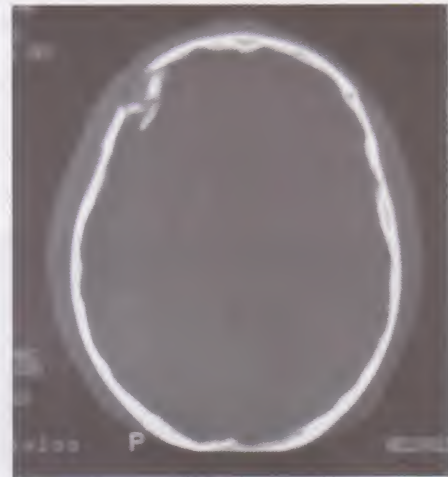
Axial CT brain (bone window) showing a depressed fracture of the skull
